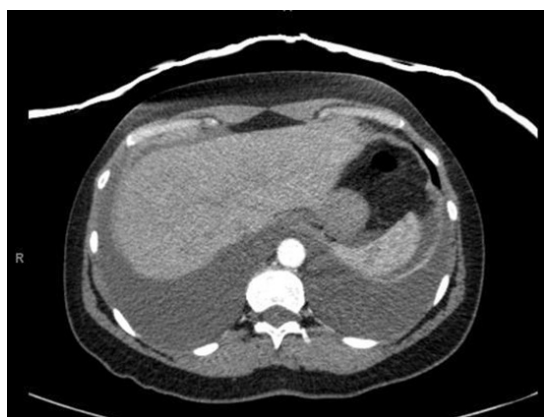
Angio-CT scan performed on the patient (bilateral pleural effusion and a small amount of perihepatic free fluid).
